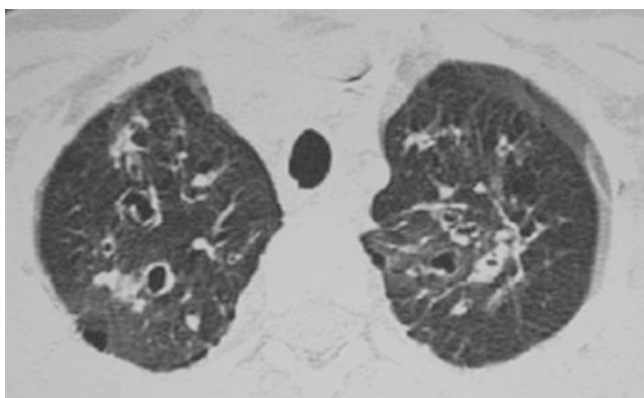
CT chest on a 14-year-old boy showing typical findings of cystic fibrosis. There is bronchial wall thickening, bronchiectasis, and areas of mucous plugging
